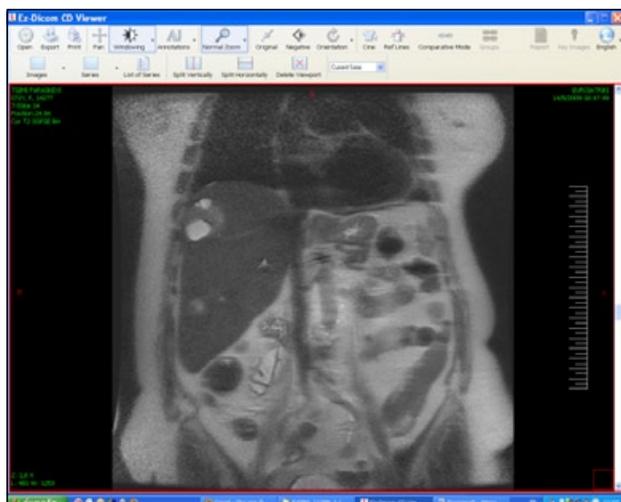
Abdominal MRI (BH-FRFS sequence). Multiple liver focal lesions ranging from 1.3-4.2cm in diameter, with heterogeneous signal due to the presence of liquid and solid components. The lesions showed enhancement within the solid part on post gadolinium images.
